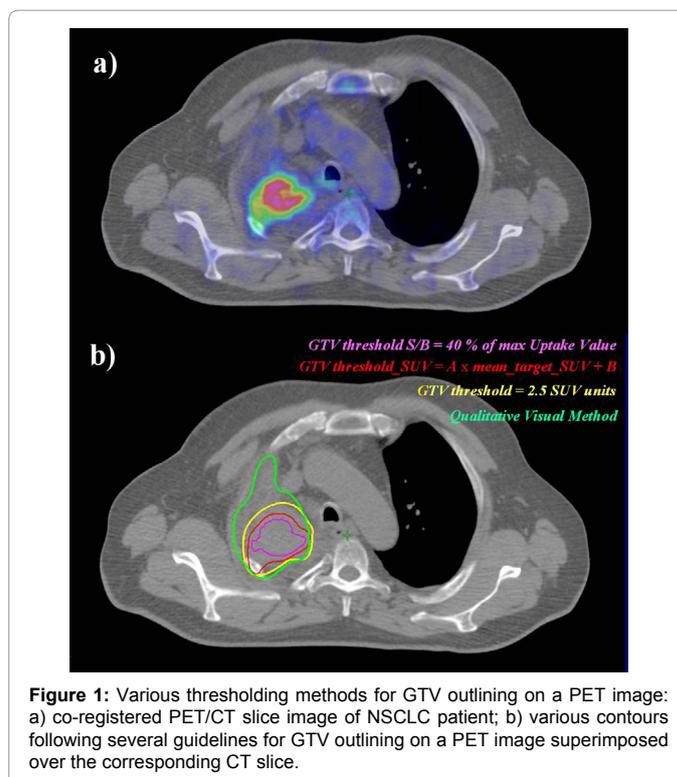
Various thresholding methods for GTV outlining on a PET image: a) co-registered PET/CT slice image of NSCLC patient; b) various contours following several guidelines for GTV outlining on a PET image superimposed over the corresponding CT slice.
